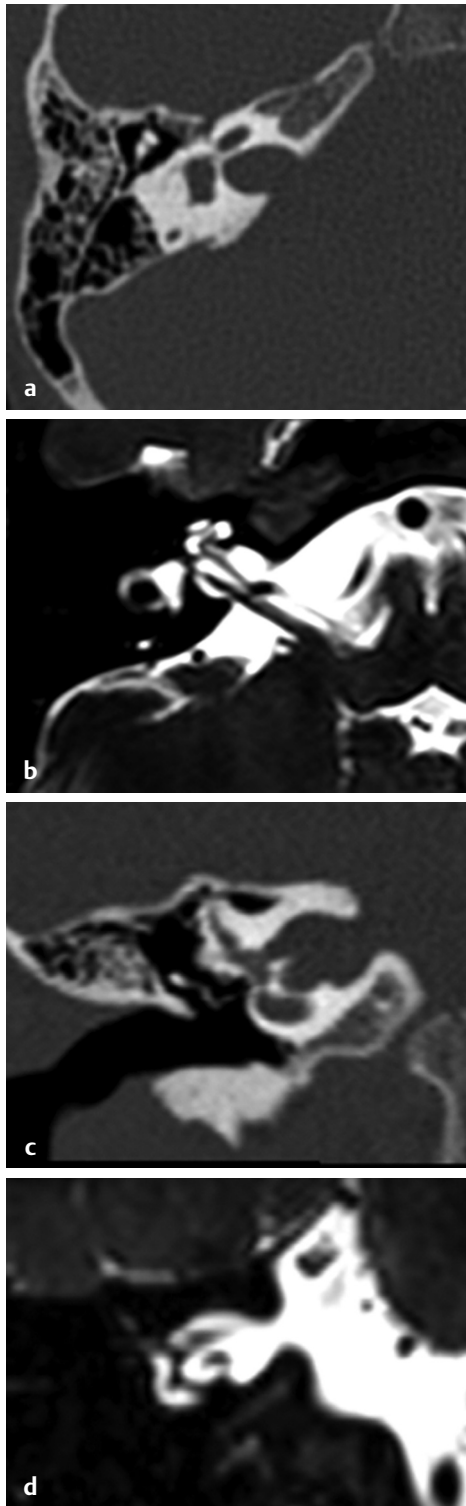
(a, c) HRCT temporal bone, bone window, (a) Axial and (c) coronal sections and (b, d) MRI CISS sequence, (b) axial sections and (d) coronal sections show widened internal acoustic canal with normal inner ear.
